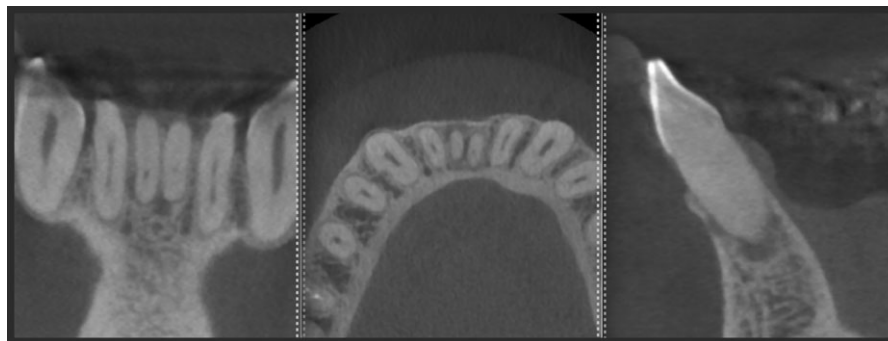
CBCT scan of the mandibular anterior teeth.
